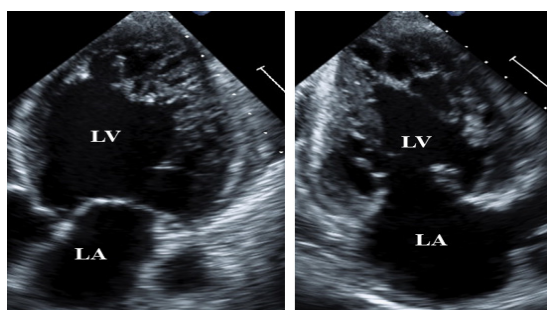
Apical three and two chamber view demonstrating noncompaction of the left ventricle. [LA-left atrium, LV-left ventricle]
